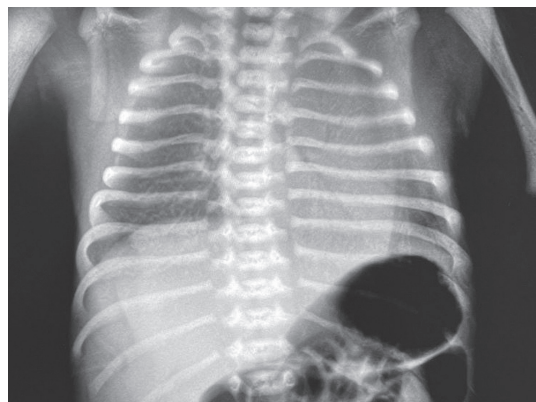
Chest X-ray of newborn with clinical signs of respiratory distress 2 hours after birth
